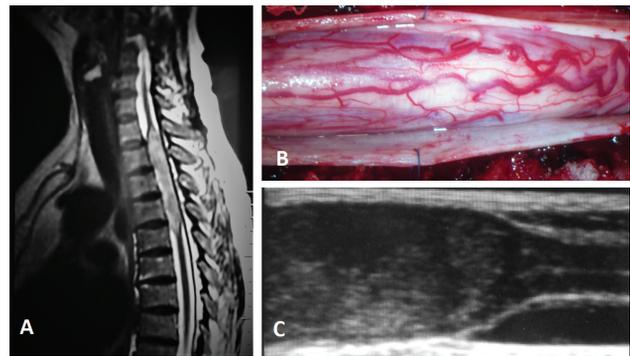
(A) Preoperative T2-weighted MRI scan showing a cervico-thoracic intramedullary tumor. (B) Surgical image showing spinal cord enlargement without precise limits. (C) The IOUS showing the tumor, slightly hyperechoic, widening the spinal cord. It is possible to distinguish the exact point in which the medulla loses its normal sonographic aspects (the high reflectivity of the medullary surface, the hypoechogenicity of the nervous tissue, and the central echo).
